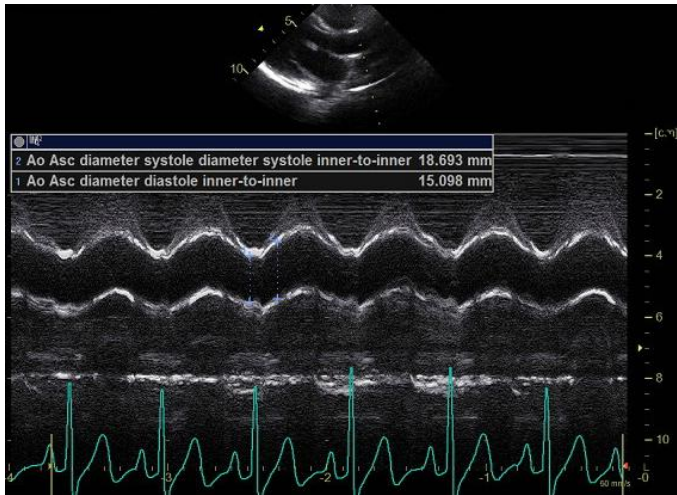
M-mode recording of the ascending aorta on the parasternal long axis. The diameter of the ascending aorta is measured from inner to inner surface in diastole and systole.
